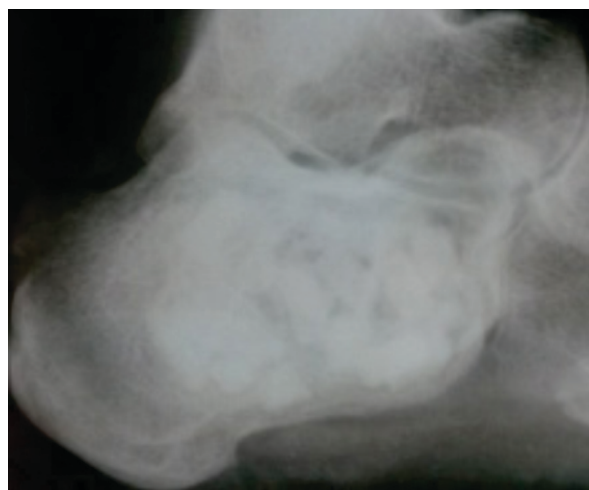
Immediate Post-op X-ray consolidation
